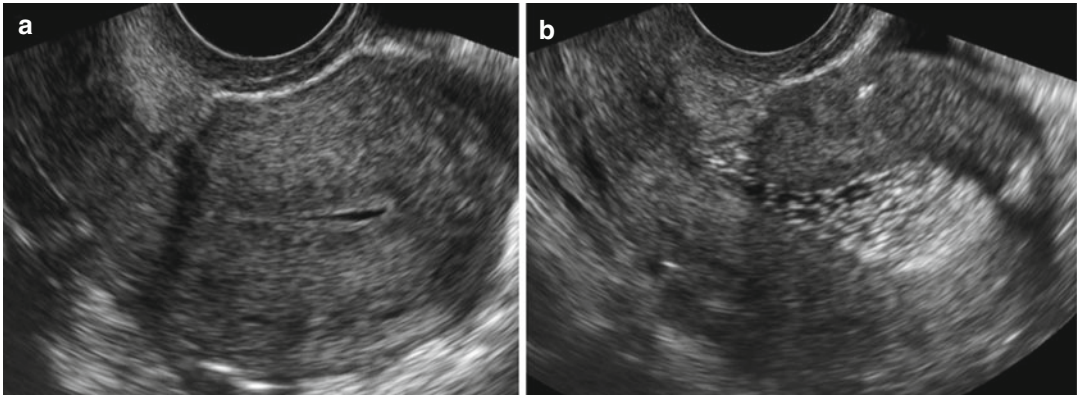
2D Ultrasound in a dysmorphic uterus U1c. (a) Pre-surgery, cavity length 18 mm and fundal thickness 13 mm; (b) Post-surgery US, cavity length 25 mm and fundal thickness 9.8 mm. contrast is due to hyalobarrier®
